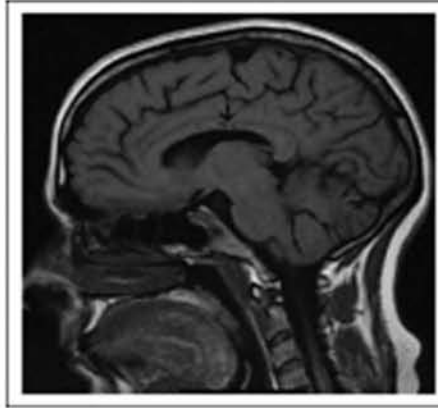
Representative MRI shows microinfarctions called "snowballs or spokes" in the corpus callosum.⁴
